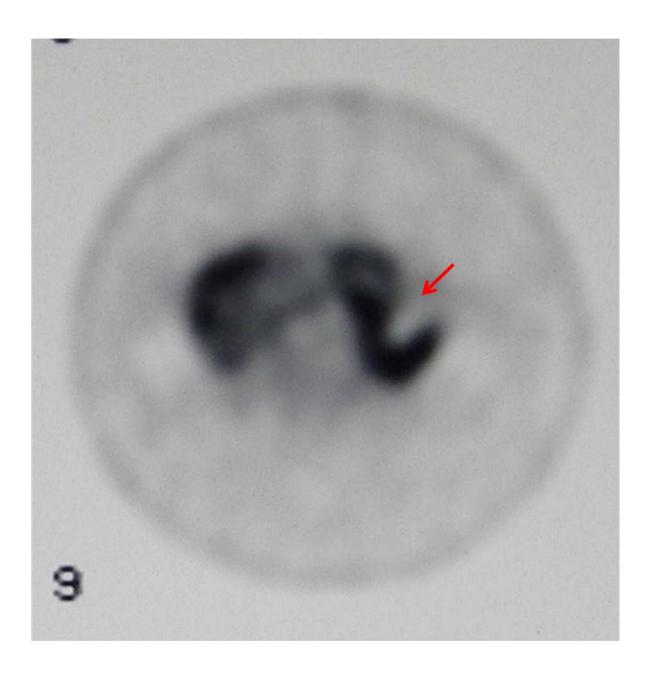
123I-IMP SPECT showed hot spot at the site of the splenic vein obstruction (arrows). Lever (arrowhead)
